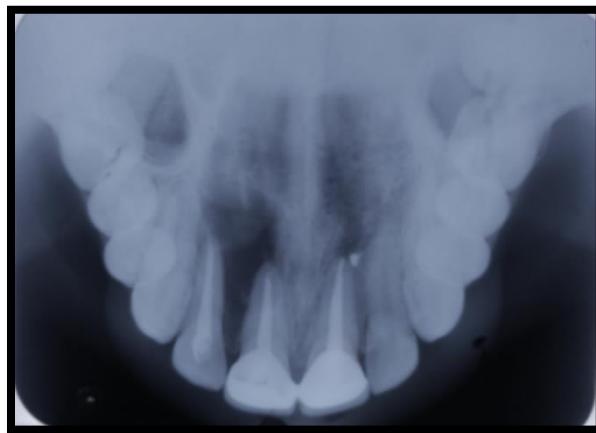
pre-operative Occlusal radiographs
